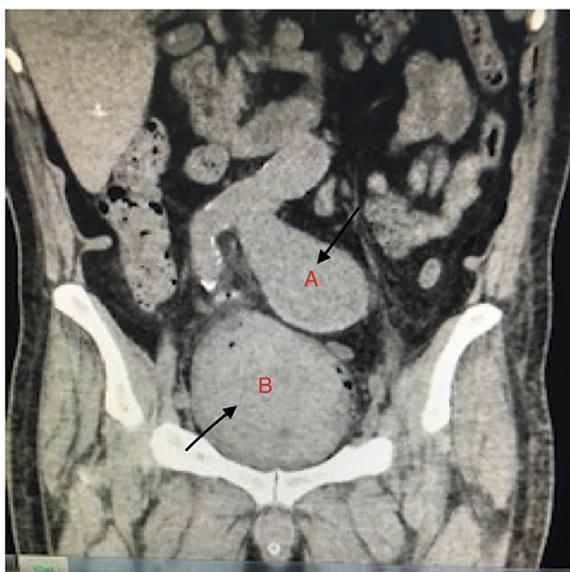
CT scan showing large left common iliac artery aneurysm compressing the distended bladder. Bladder is full with blood clots. Aneurysm (A), Bladder (B).
